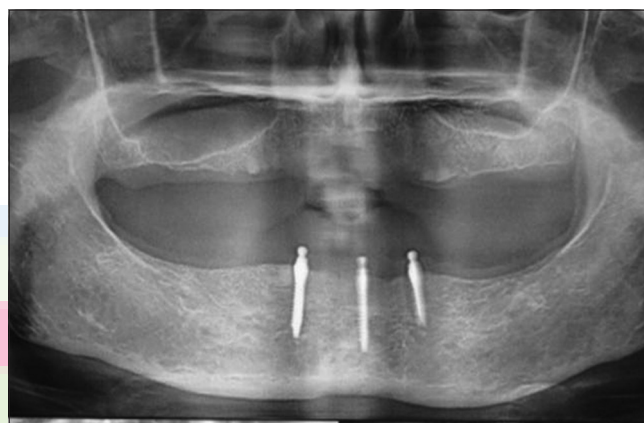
Orthopantomogram showing osseointegrated implants after 14 weeks of surgery
